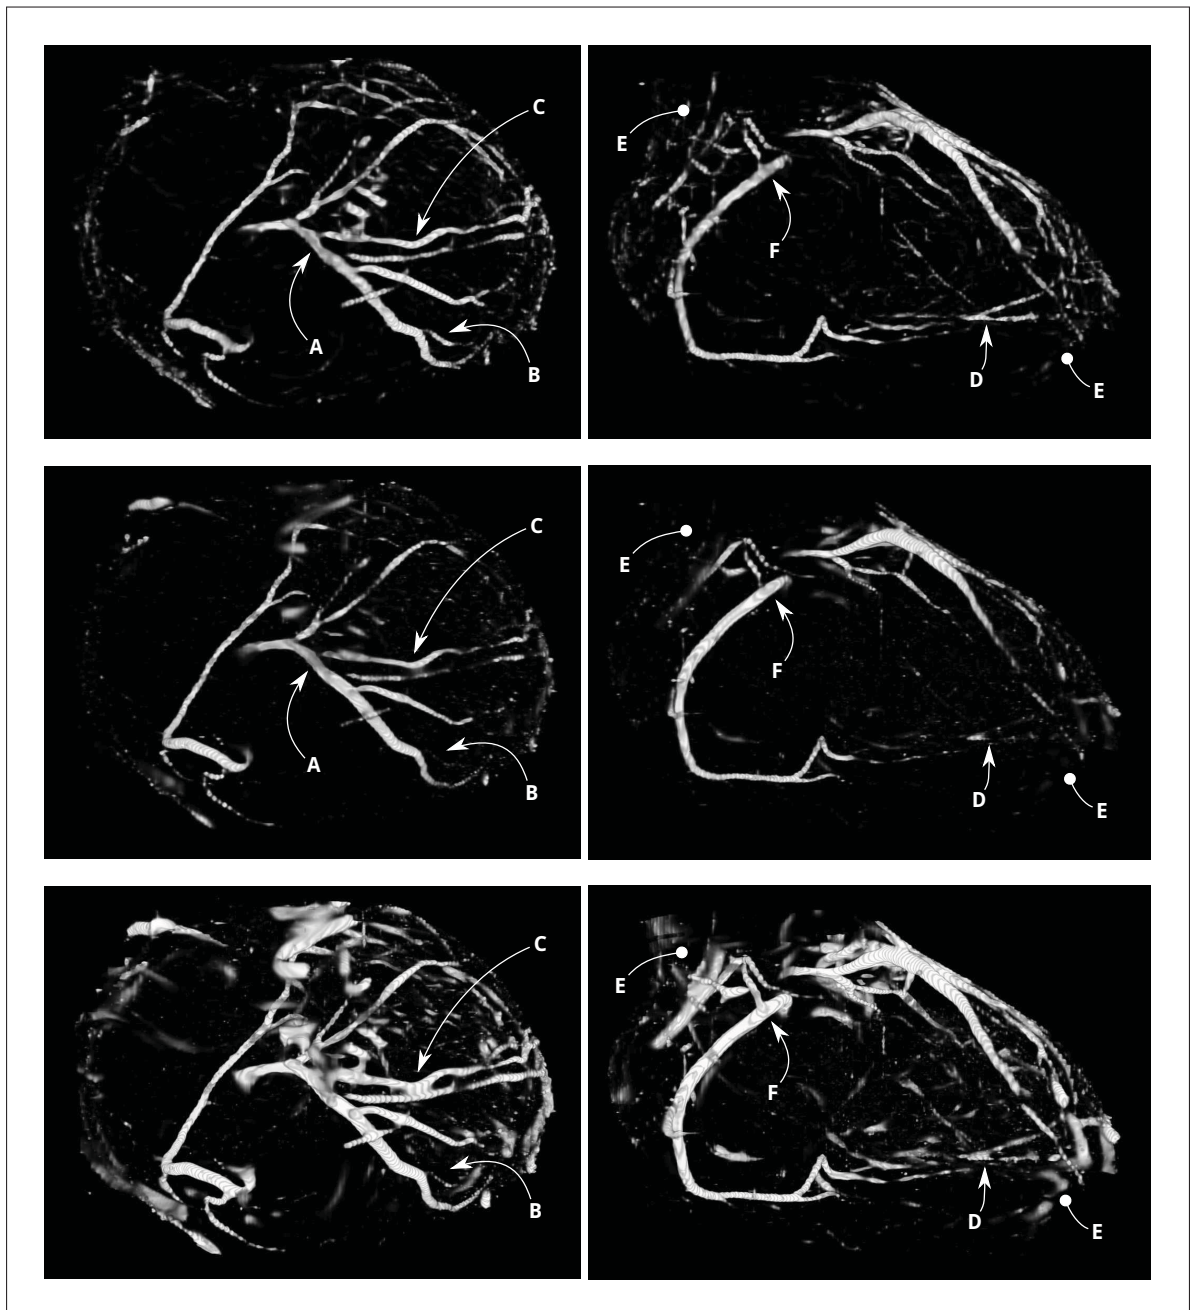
Vessel detection in a cropped clinical cardiac CTA volume. *Left column:* axial superior view, and *right column:* sagittal anterior view. *Top to bottom:* vesselness response for the SBall filter, Frangi's filter, and Sato's filter. The arrows indicate some regions of interest. See the text for a discussion.
